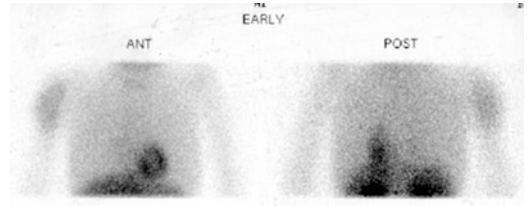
Pre-chemotherapy thallium scintigram
